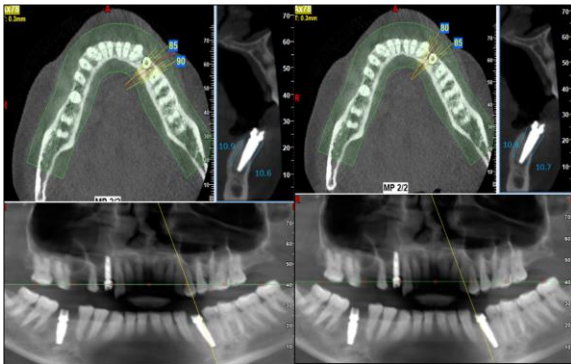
Crestal Bone loss evaluation by CBCT on distal & mesial aspect of 34 (Protocol A)
